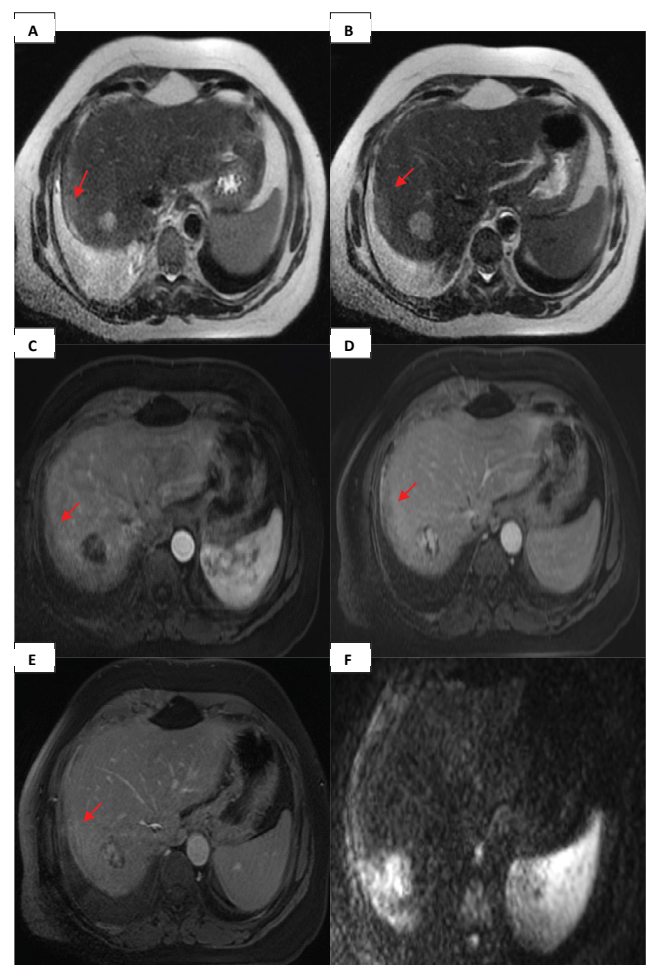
Liver MRI axial views: (A, B) T2-weighted images on two successive levels, (C,D,E) T1-weighted post contrast images obtained at different time intervals after injection of the gadolinium, (F) Diffusion-weighted image.
